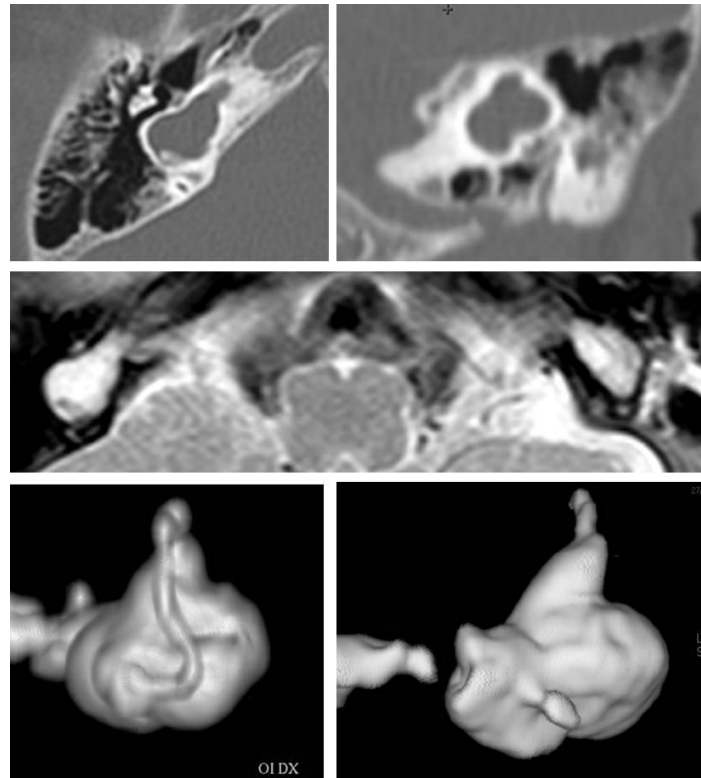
CT and MRI temporal bone scans with 3-D MR imagines showing bilateral hypoplastic cochlea with normal basal turn.
